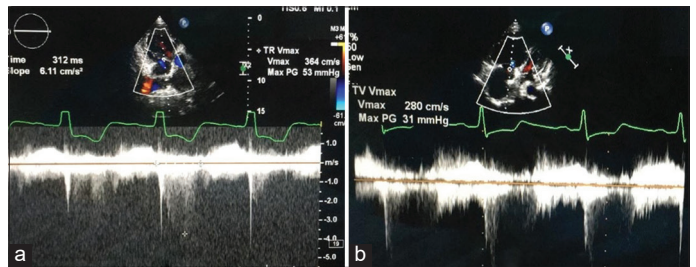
Echocardiography parameters before (a) and after (b) cardiac rehabilitation program
